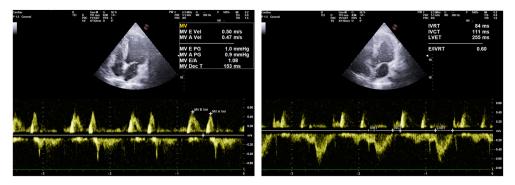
Figure nr. a.2.5. Measuring different heart cycle time intervals: DecT, deceleration time (153 ms); IVCT, isovolumic contraction time (111 ms); ejection time, LVET (255 ms); IVRT, isovolumic relaxation time (84 ms), Tei index=0.76 (PW Doppler, apical 5-chambers view)
